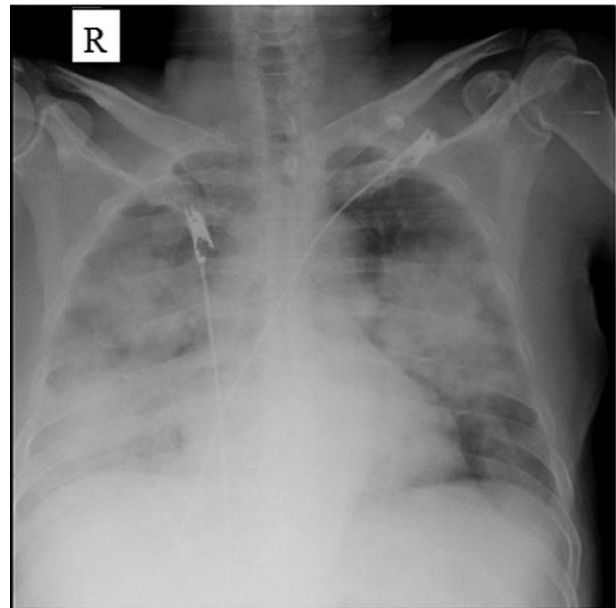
Chest X-ray revealing multiple infiltrates in both lungs.
